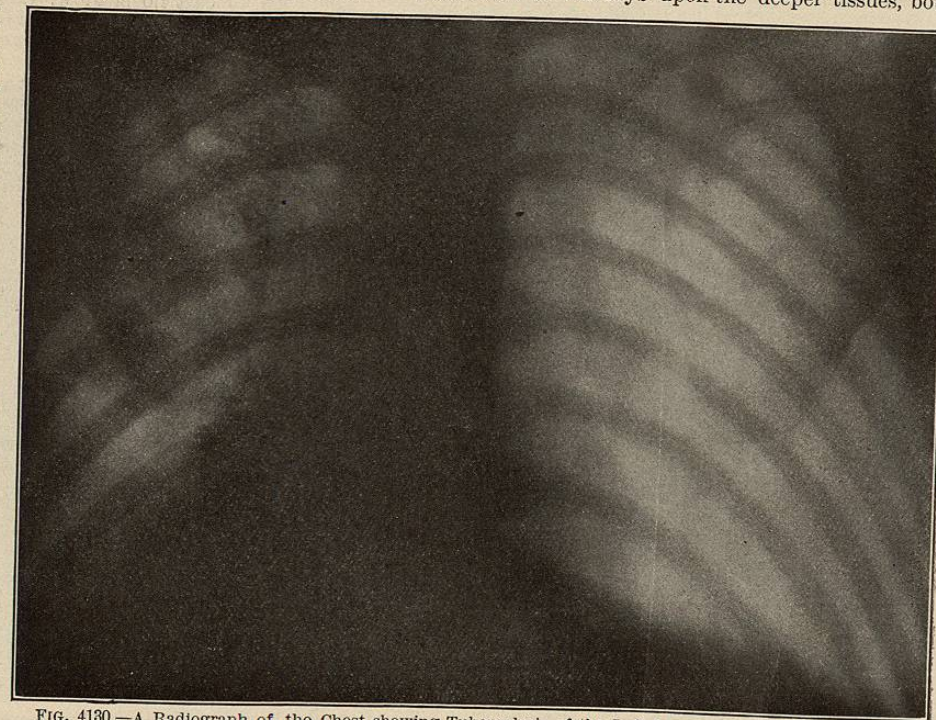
A Radiograph of the Chest showing Tuberculosis of the Left Lung; the Right Lung Normal. (Ziemssen-Rieder.)
